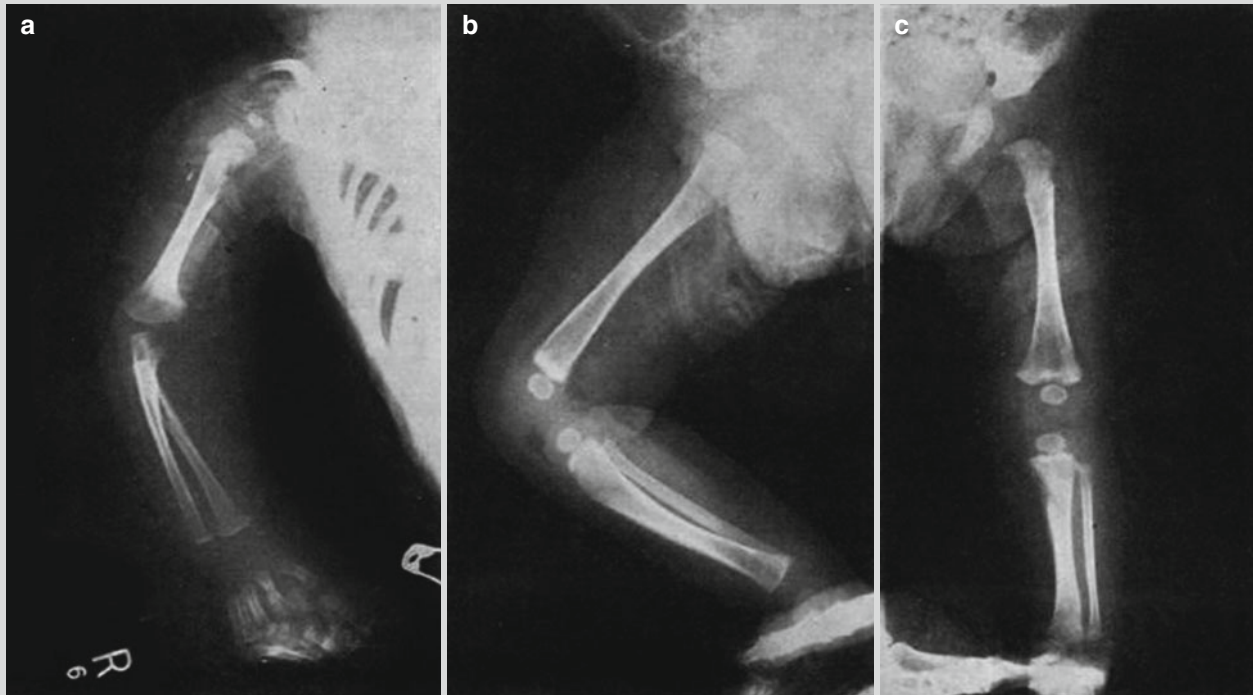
Syphilitic metaphysitis and periostitis. (a) X-ray demonstrates parallel thickening of periosteum at the right radius and ulna and transparency shadow below the metaphysis. (b) Thickened prior
